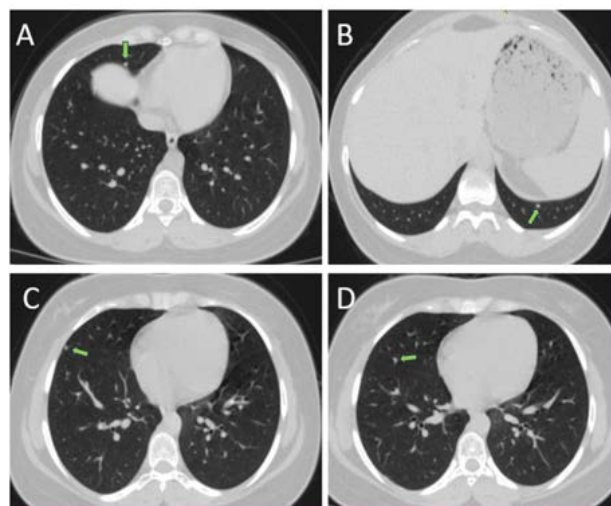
Axial CT image in Lung Window Shows Multiple Randomly Distributed Nodular Lesions in Bilateral Lung Fields. A Possibility of Multifocal Micronodular Pneumocyte Hyperplasia was Considered
